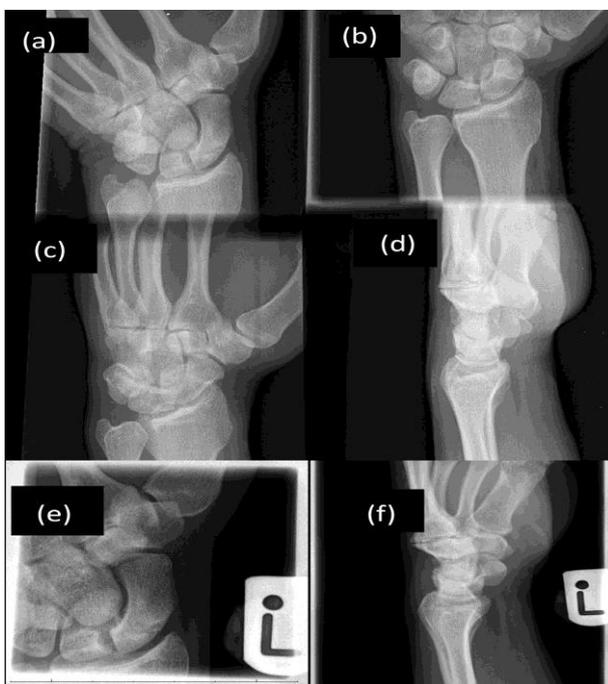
Missed scaphoid fracture from initial X-ray, then diagnosed after 2 weeks repeat X-ray. (a-d) initial X-ray of the wrist shows normal views. (e-f) are radiographs taken after two weeks and revealed proximal pole of scaphoid fracture
